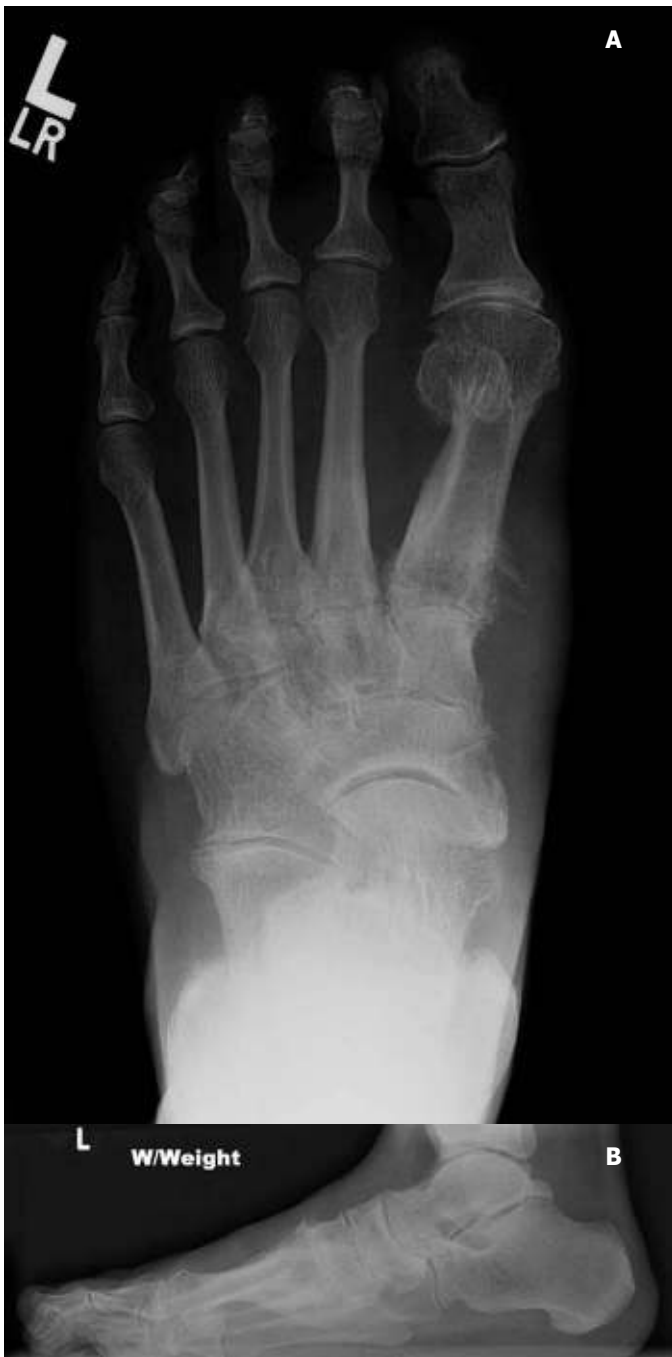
and 1B Initial anterior posterior (AP) (A) and lateral (B) radiographs demonstrating soft tissue edema with early signs of osteolysis, cortical thickening, fragmentation, and osseous destruction within the tarsometatarsal and naviculocuneiform joints.
